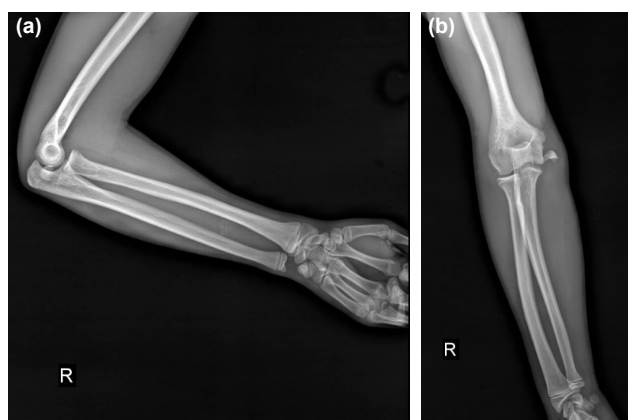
The displaced medial epicondyle fracture of humerus is shown on anteroposterior (a) and lateral (b) radiographs of the right elbow.
